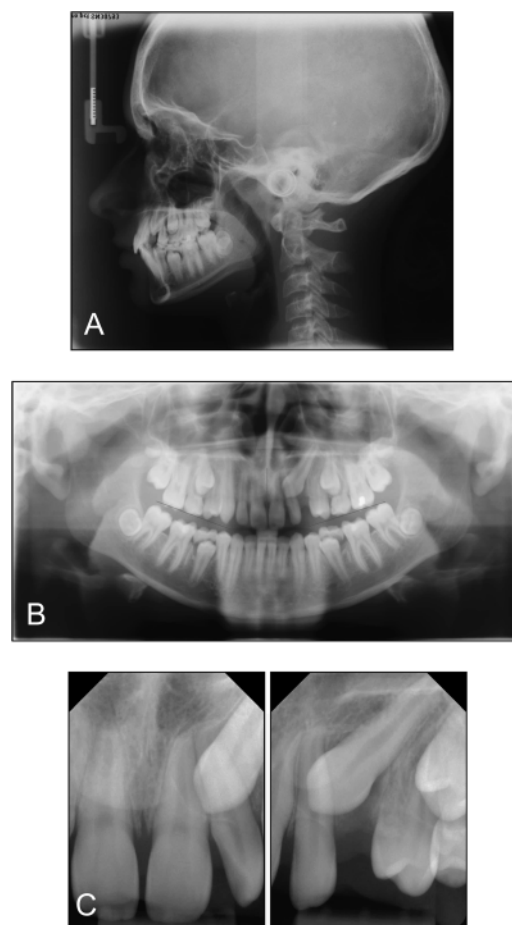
Example of a two-dimensional data set composed of digital radiographs: (A) lateral head film, (B) dental pantomograph, (C) periapical radiographs with different projections.
